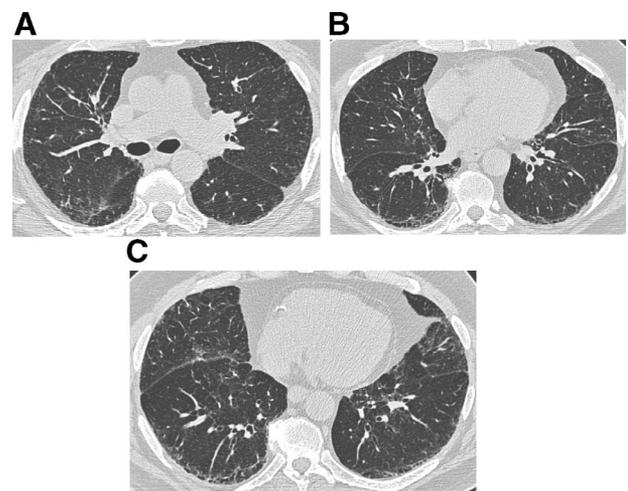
Axial (A-C) images from HRCT demonstrate peripheral and basilar predominant reticulation, and traction bronchiectasis, without subpleural honeycombing consistent with probable UIP (possible UIP).
